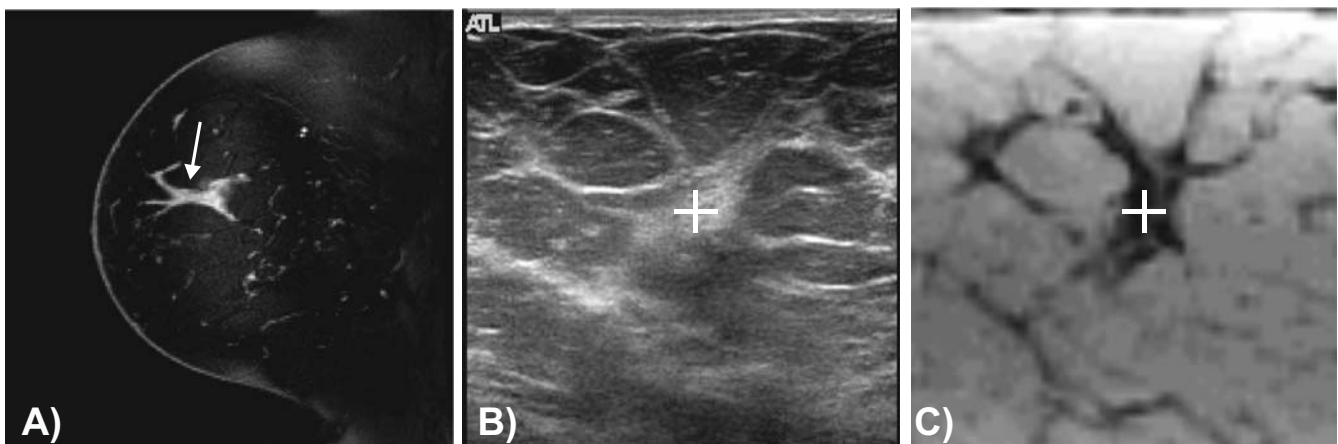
DCE-breast MRI (a) showing an enhancing lesion (arrow). Using optical co-registration, the subsequent ultrasound imaging of the same lesion (b) is aligned with the MRI without fat suppression (c).
